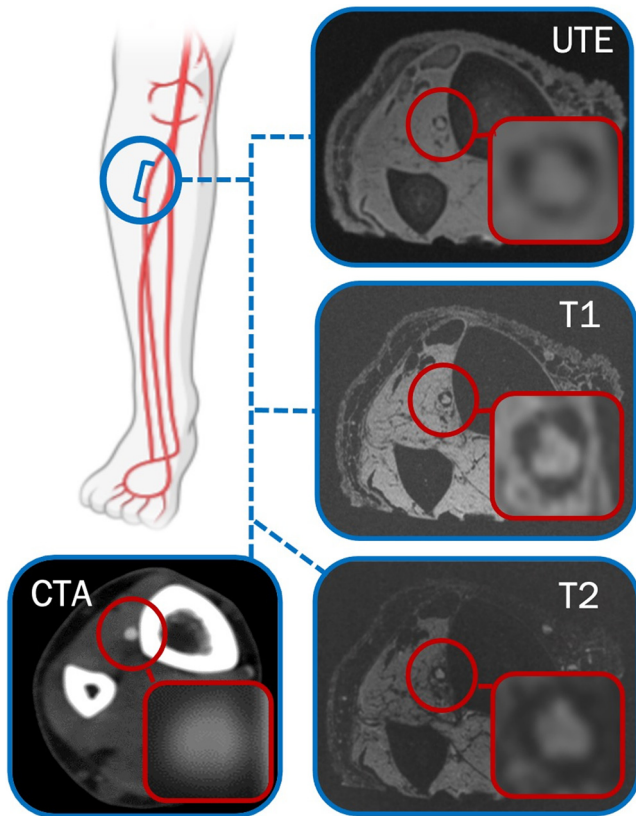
Anterior tibial artery plaque morphology on 7T magnetic resonance imaging (MRI) and computed tomography angiography (CTA). The 7T MRI images (ultra-short echo time [UTE], T1, T2) show a detailed structure of a concentric, calcified plaque with calcium as a signal void. Assessment on the CTA image is limited because of extensive calcification and consequential blooming artifact.
